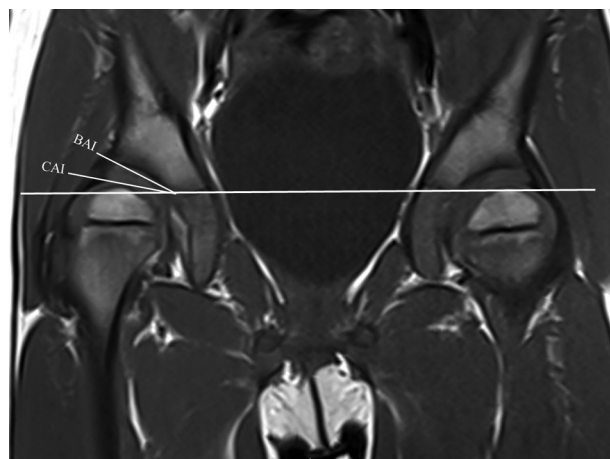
MRI showing divergent dysplasia with BAI = 30, CAI = 11, and $CAI^2/BAI = 4$.
